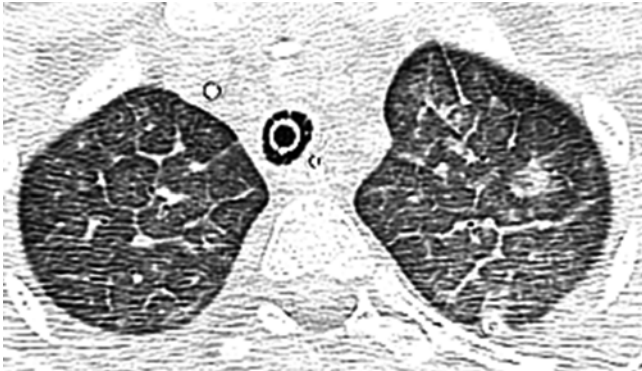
Pulmonary alveolar proteinosis in an 8-year-old girl. Axial lung window CT image shows bilateral ground-glass opacities with smooth intra- and interlobular septal thickening in polygonal shapes, an appearance known as crazy paving
